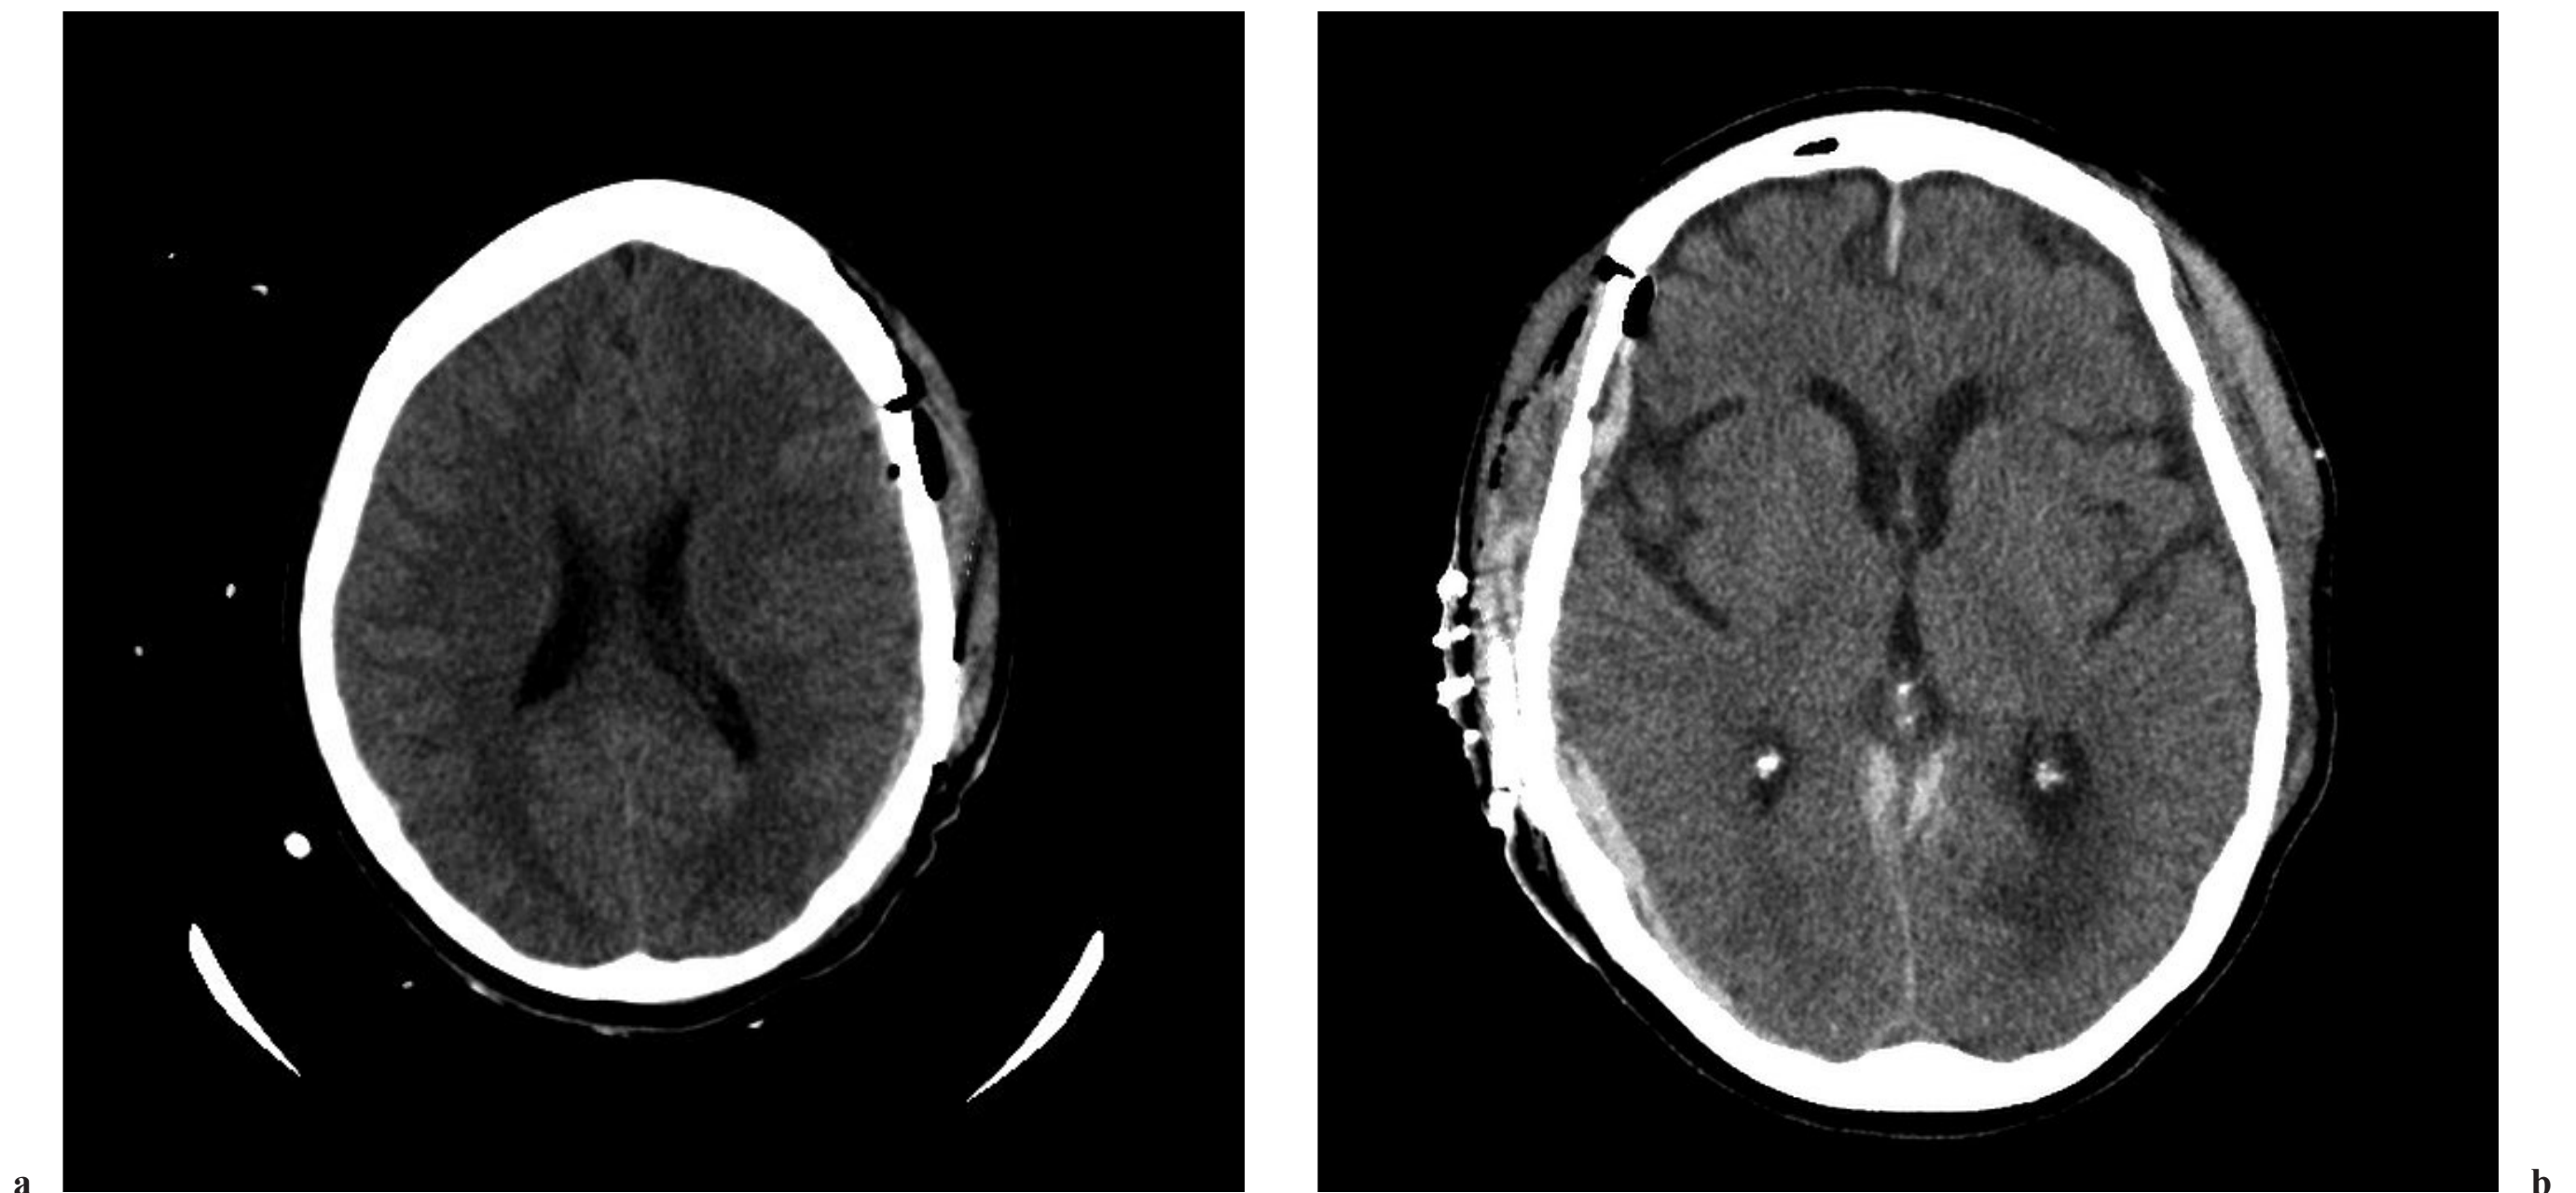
Axial CT images demonstrating resolution of (a) epidural hematoma and (b) subdural hematoma.
